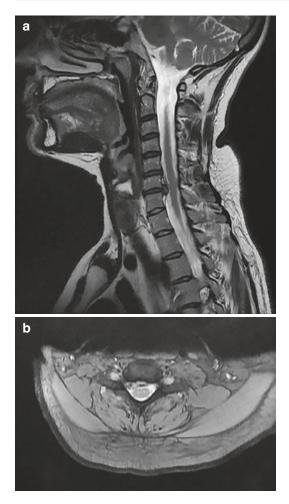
Indications for anterior cervical discectomy and fusion: cervical radiculopathy. A patient with a C6-7 disc herniation causing right-sided nerve root compression and spinal cord compression. (a) Sagittal T2-weighted magnetic resonance image (MRI) demonstrating the degree of spinal cord compression. (b) Axial T2-weighted MRI demonstrating a broad-based disc herniation compressing the exiting nerve root of C7 on the right and the ventral aspect of the spinal cord. The nature of such compression requires a ventral approach to adequately decompress the entire segment. In this case, a posterior minimally invasive cervical foraminotomy with discectomy would not offer comprehensive decompression of the nerve root and spinal cord, given the degree of ventral compression. (Used with permission from Barrow Neurological Institute, Phoenix, Arizona)
